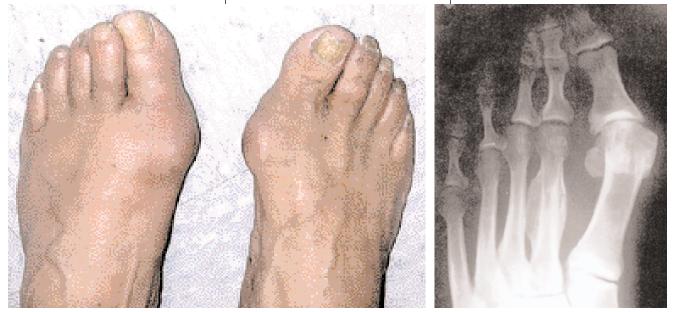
/B. Case Presentation. This 55 year old male presented with a 2-week history of pain and swelling in dorsum of the left foot (Figure 5A). The patient had hallux valgus deformity of the left foot only and a history of gouty arthritis. The problem failed to resolve after 2 weeks and in fact showed some signs of increased pain and swelling after he walked on it. There was no history of trauma; however, plain radiographs revealed fracture of the 2nd metatarsal (Figure 5B). Unilateral hallux valgus did not account for this patient's pain and swelling. Similarly, although the patient had a history of gouty arthritis, the pain and swelling was lasting 2 weeks without showing signs of improvement, which is unusual for gout. Although this patient had no history of trauma, plain radiographs revealed a healing fracture of the second metatarsal which might have become more symptomatic with walking on the foot.
